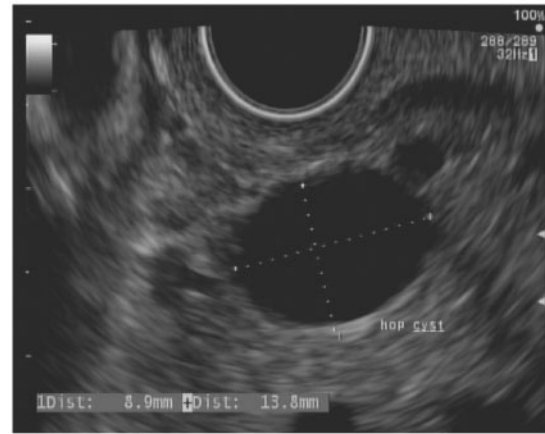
Endoscopic ultrasound view of pancreatic cyst (8.9mm x 13.8mm) in the head of the pancreas.
